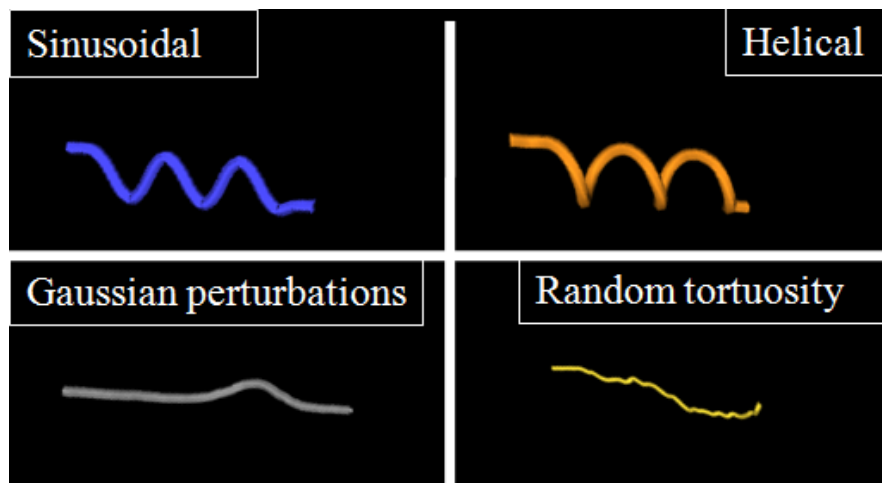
Example centerline segmentations corresponding to the ultrasound data in Figure 4.6
